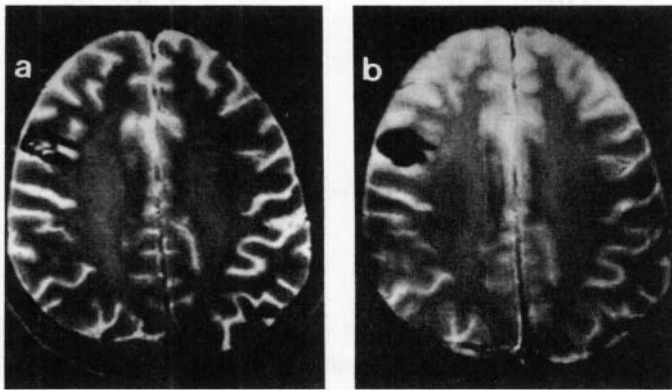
Cavernous angioma. T2-weighted axial image (a) showing a heterogeneous area with a peripheral hypointense rim in the right frontal region. On GRE image (b) the lesion shows T2\* effect.
